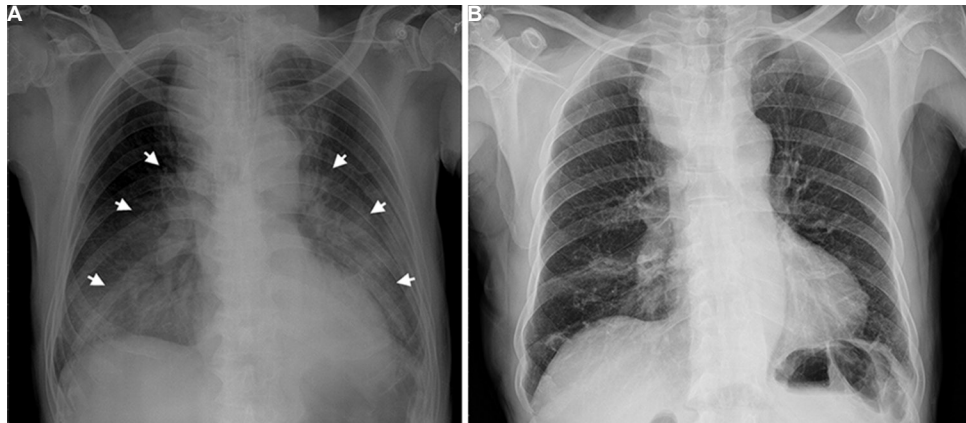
Chest radiographs showing diffuse, bilateral infiltrates consistent with pulmonary oedema following tracheal stent implantation (A, arrows) and obvious improvement in the lung fields after adequate positive pressure ventilation (B).
